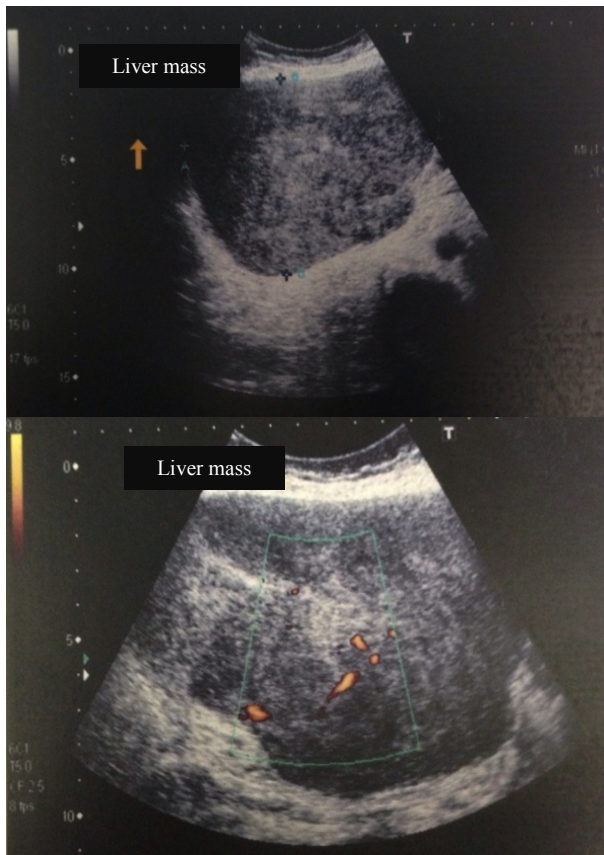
A) Abdominal ultrasound: shows solid hyperechoic liver tumor. B) Abdominal ultrasound: vascularized nodule on Doppler.
